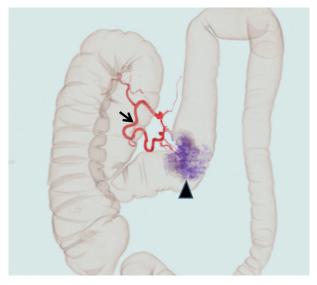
CTC air image and 3D-CT angiography fusion image. The stenotic lesion showed as a purple fog (arrow head) in the transverse colon is being fed by the left branch of the middle colic artery (arrow). Laparoscopic left hemicolectomy and D2 dissection were performed under navigational guidance.
